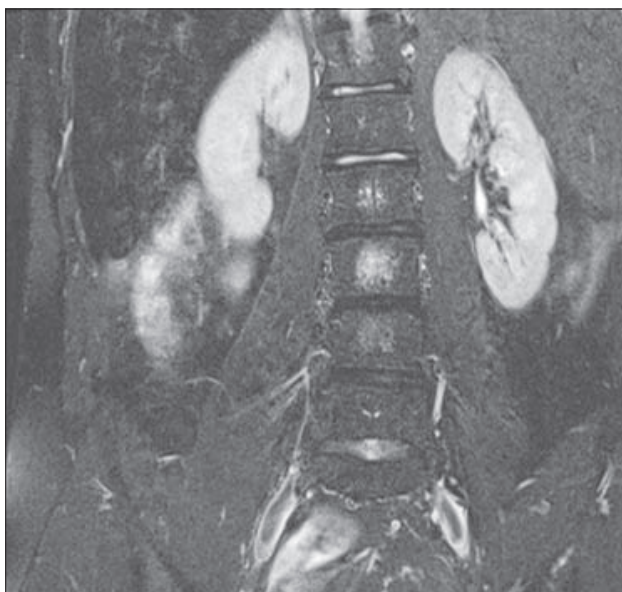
MRI of spinal cord shows osteolytic changes of Th12, L3, hypoechoic cortical lesions of both kidneys.
